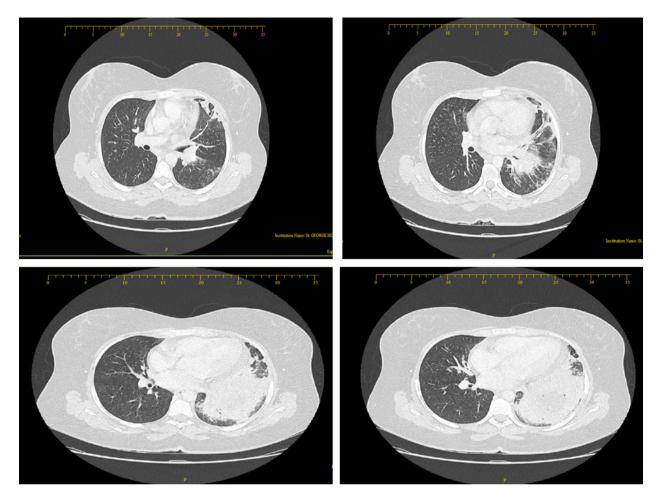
CT scan, lung view, showing the left lower lobe consolidation.
